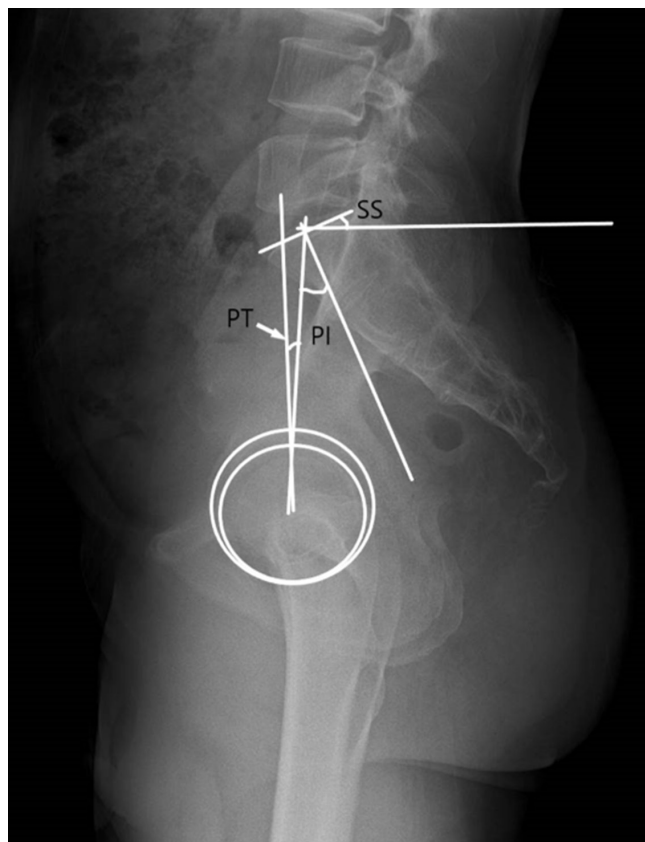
Lateral x-ray image of a 48-year-old man showing spinopelvic parameters: pelvic incidence (PI), pelvic tilt (PT), and sacral slope (SS).
